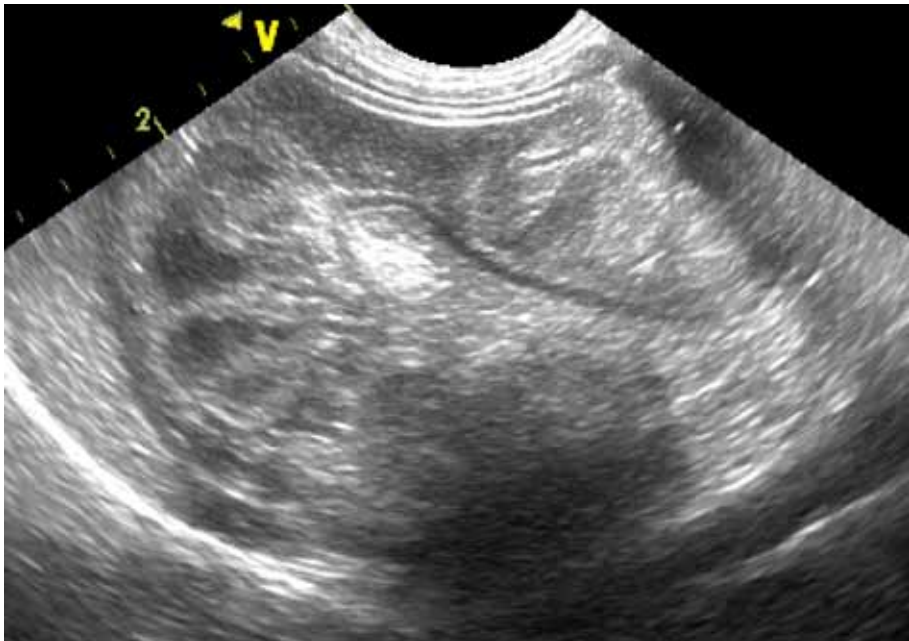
Ultrasonographic examination of the pylorogastric intussusception. Sagittal image of the intussusception. Pylorus was displaced into the fundus.
